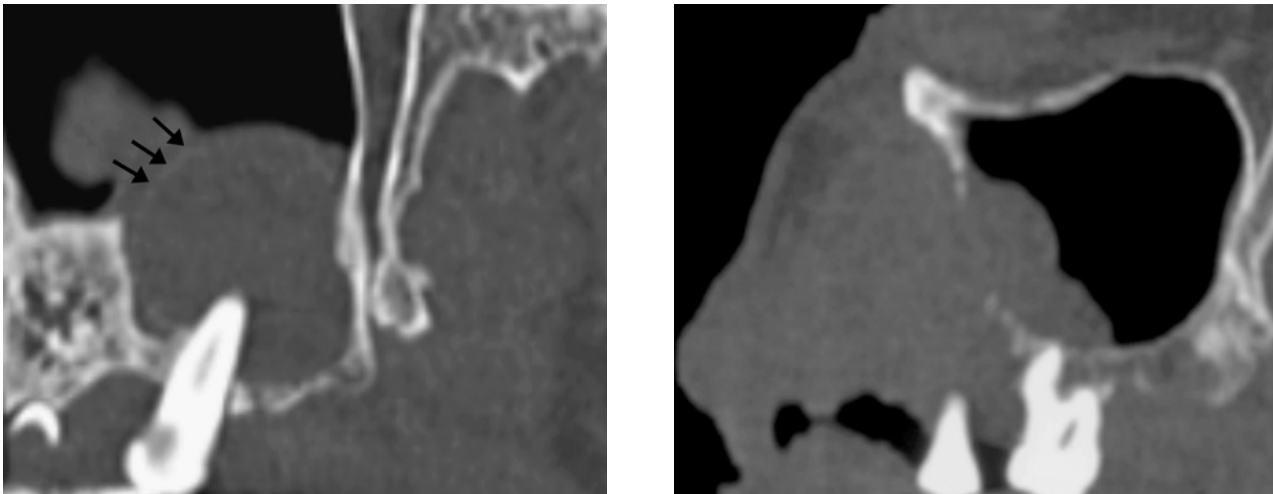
Radicular cyst (left) versus squamous cell carcinoma (right) of the maxilla on reformatted cross-sectional CT showing bowing of sinus wall seen as a very thin plate of cortical bone (arrows) due to cyst expansion (left) in comparison to erosion of sinus wall due to infiltrating carcinoma (right).
